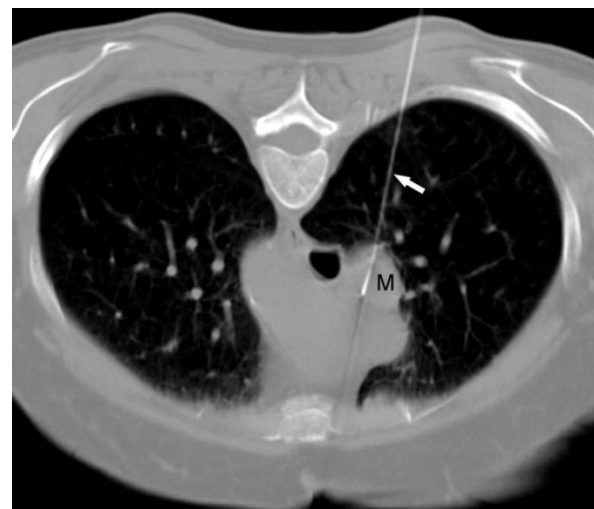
CT scan with needle placement (arrow) for transpulmonary biopsy [GUP05]
